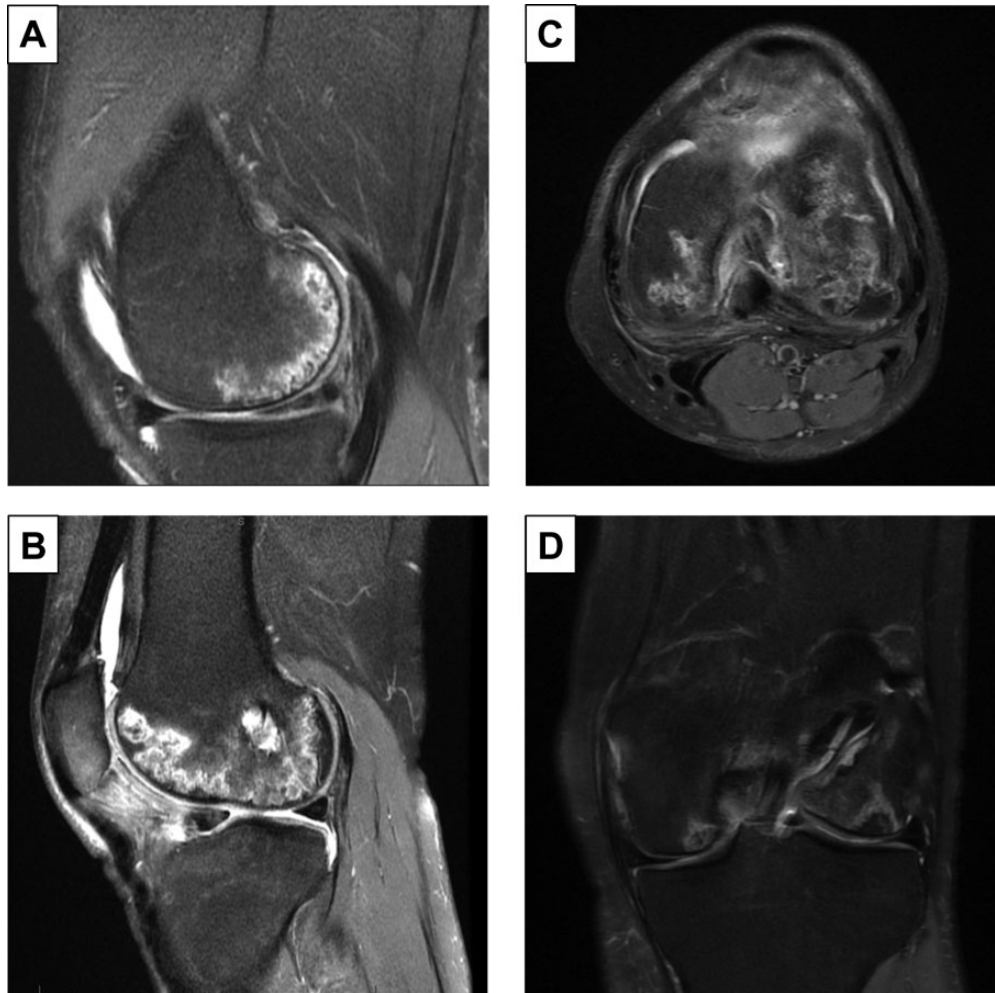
Fat-saturated, T2-weighted magnetic resonance images of the knee of patient 3: (A) sagittal image of the medial femoral condyle, (B) sagittal image of the lateral femoral condyle, (C) axial image of both femoral condyles and patella, and (D) coronal image of both femoral condyles and femoral tunnel.
